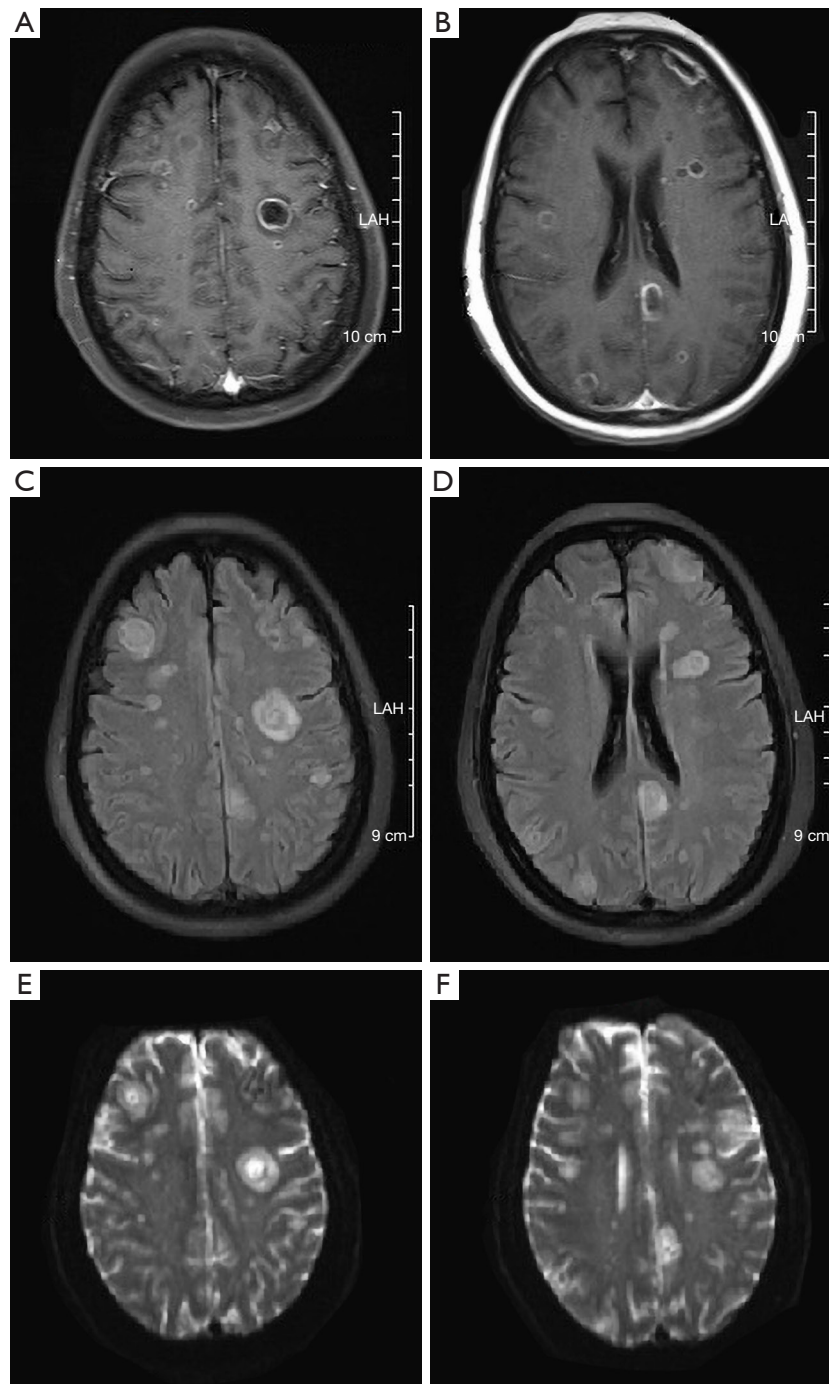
Contrast-enhanced head MRI. (A) Multiple abnormal foci in the bilateral cerebrum and cerebellum. (B) Hypointensities on T1. (C,D) Hyperintensities on T2. (E,F) Partial bullseye sign after contrast enhancement. LAH represents the left side. MRI, magnetic resonance imaging.
